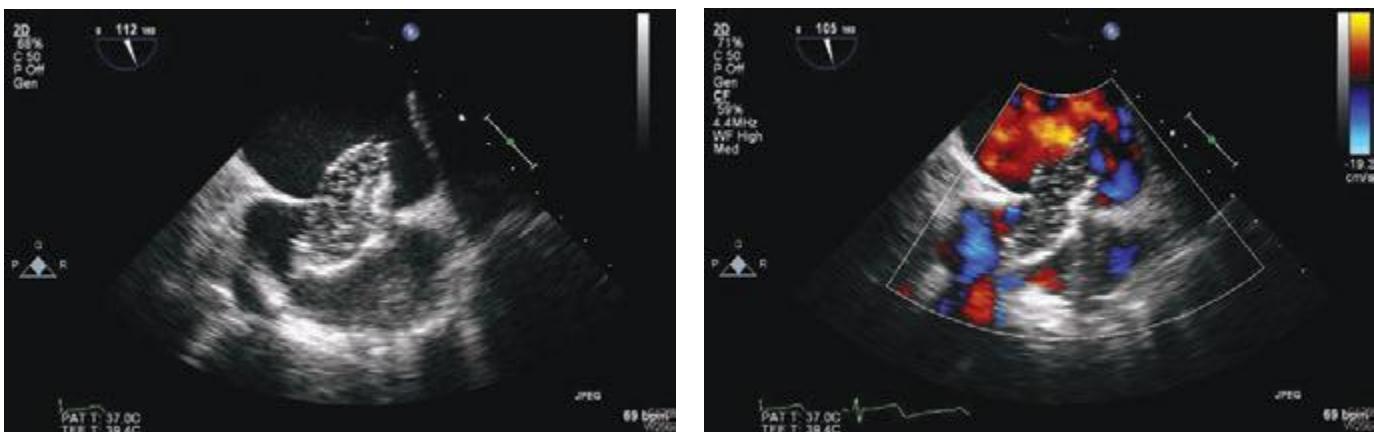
19 Transesophageal echocardiogram showing sizing balloon (left) and no flow (right) across the atrial septal defect.
